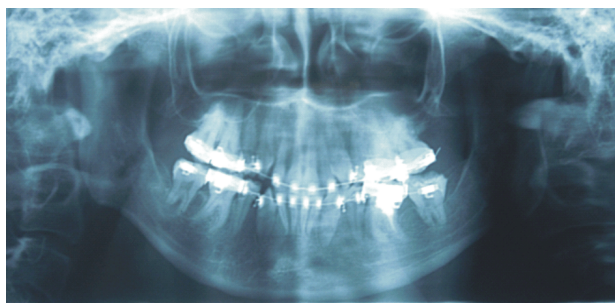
Panoramic X-ray during treatment, with MM2 included in the appliance and uprighted.
